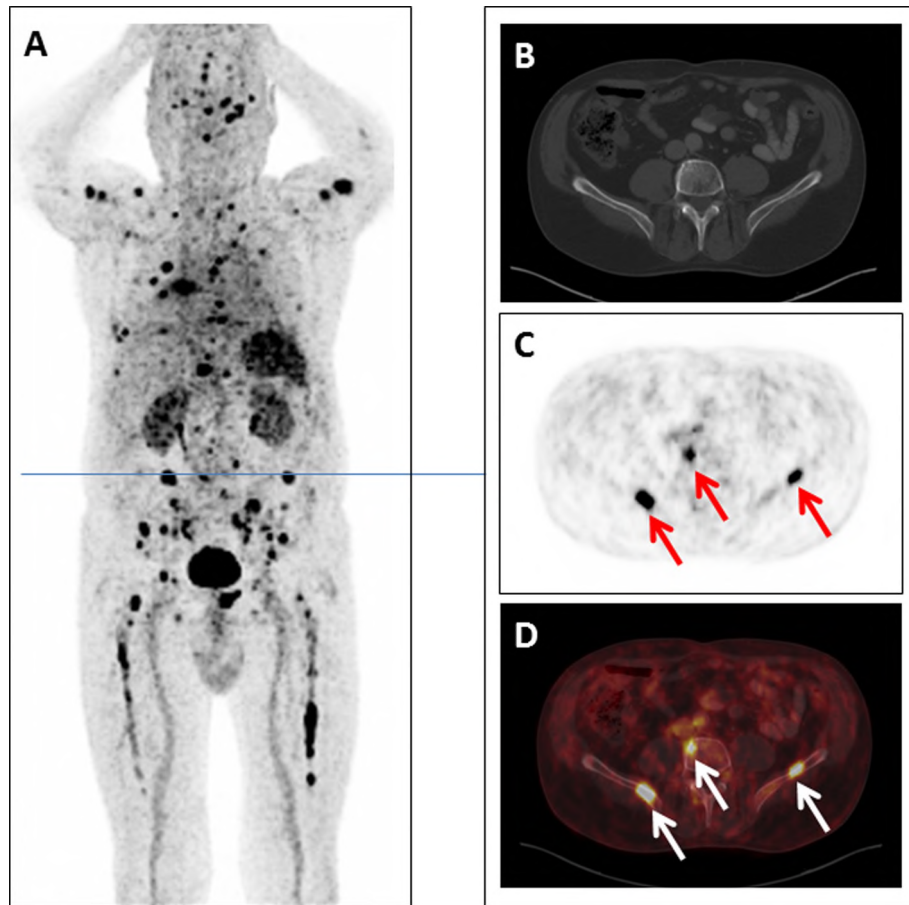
A) Whole-body view of [^{68}Ga]Pentixafor PET/CT (60 min p.i.) in a patient with multiple myeloma. Multiple hot spots can be detected in the skeleton (in the ribs, long bones and the pelvis), implicating high focal CXCR4 expression in myeloma lesions. Tomographic sections of the pelvis are shown on the right with only minimal bone destruction visible at spiral CT (B). Intense focal CXCR4-expression in skeletal structures can be seen at tomographic PET section (C, arrows) and the corresponding PET/CT image (D, arrows).
